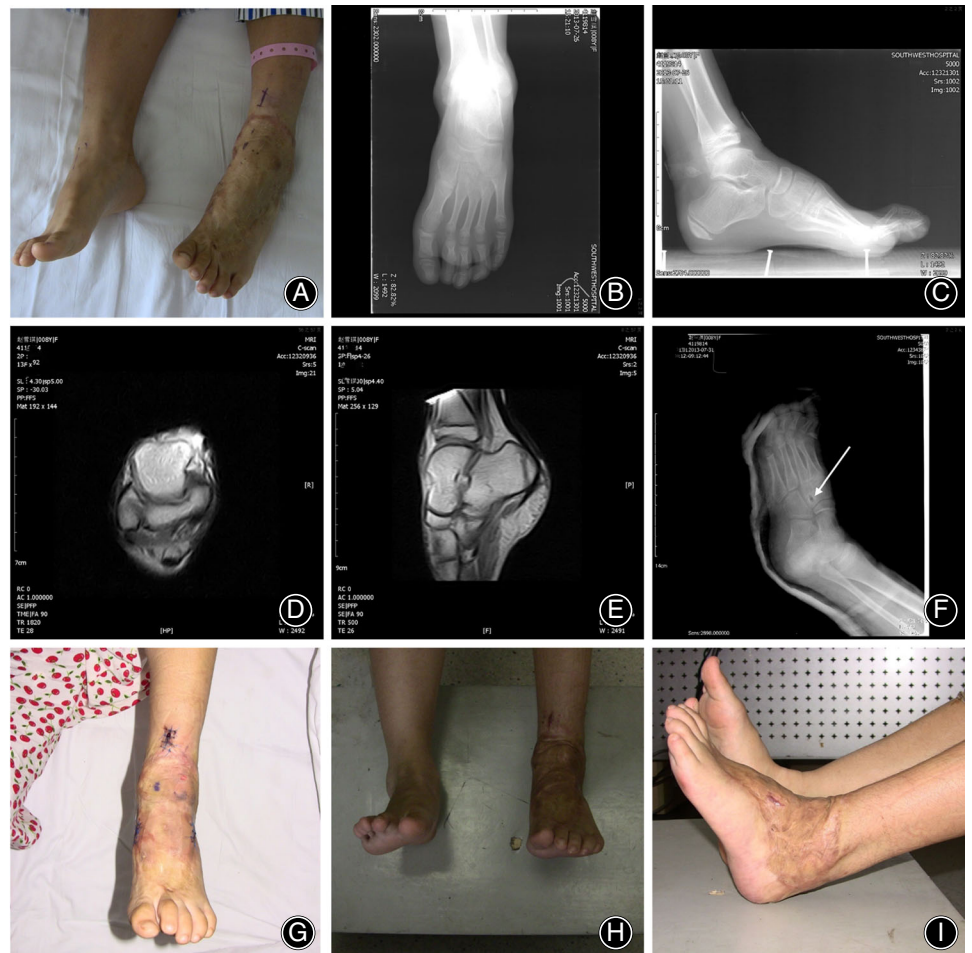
Typical Case 1: (A) general observation before surgery; (B, C) preoperative anteroposterior and lateral radiographs of the left ankle joint; (D, E) preoperative MRI examination of the left ankle joint; (F) postoperative radiograph of the left foot (the arrow indicated that the transposition tendon was inserted into the lateral cuneiform bone); (G) the incision of the transposition tendon at 3 days postoperatively; (H, I) general observation of the left ankle joint at 3 months postoperatively, which was significantly improved compared with before surgery, and the plantigrade foot was restored.
